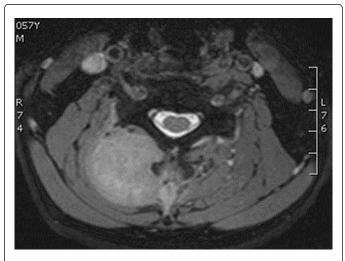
Axial image of cervical MRI before radiotherapy
